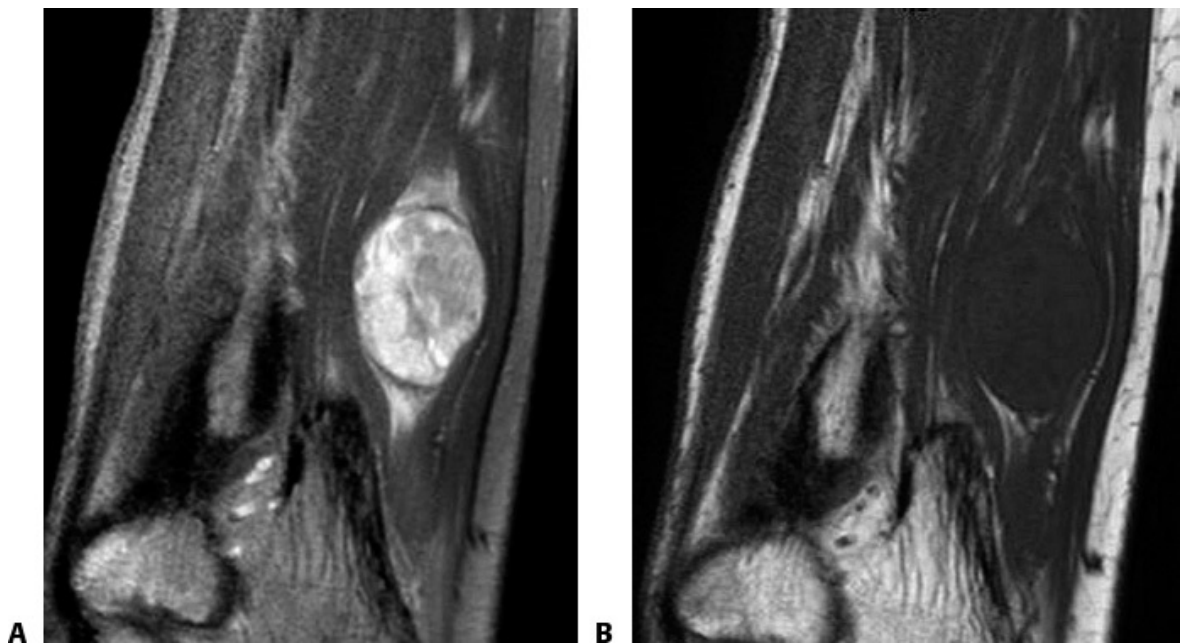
• MR images of an ulnar nerve schwannoma. A. T2-weighted image with bright appearance of the schwannoma. B. T1-weighted image has an intermediate signal intensity due to the presence of fat within the tumor.
